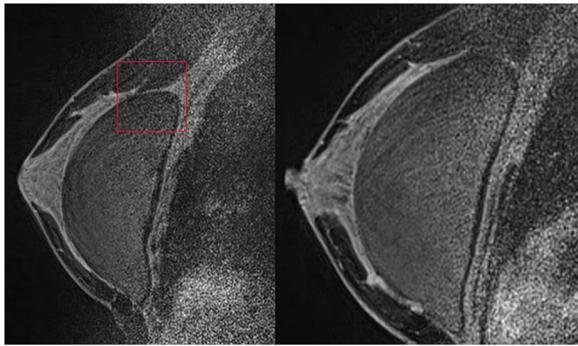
Magnetic resonance imaging of a patient with breast implants in different planes. The left implant placed in the subfascial plane (image enhancing the fascia covering the top of the implant). The right implant located in the subglandular plane (noticeable absence of fascia coverage at the top of the implant)
